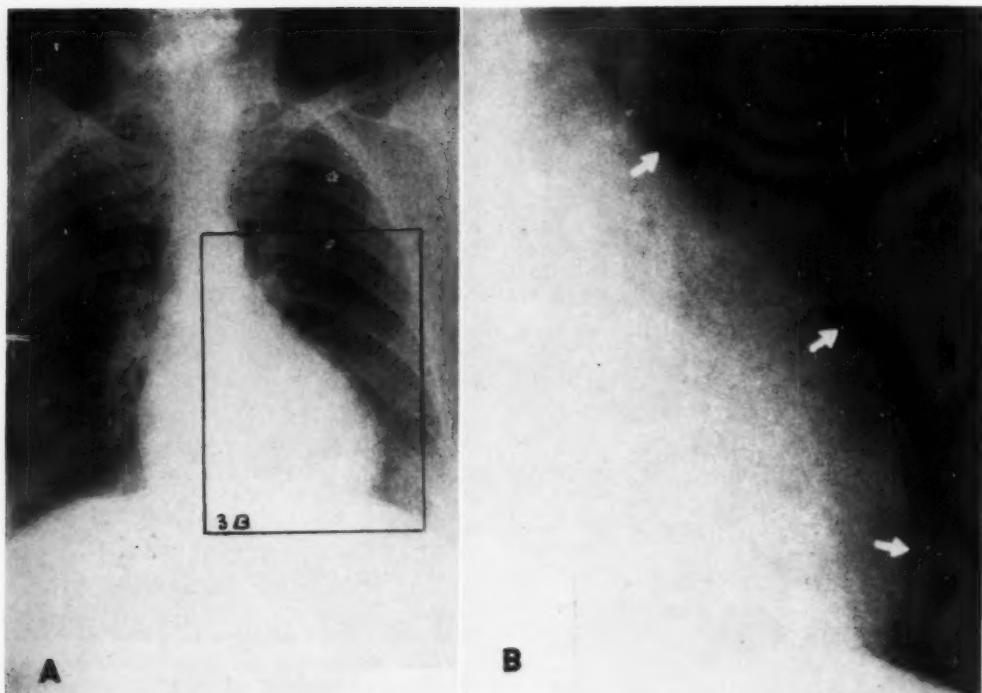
A. Roentgenogram of chest of a 61-year-old female, demonstrating the normal subepicardial-pericardial shadow pattern along the left heart border. B. Enlarged reproduction of indicated segment in 3A. All of the photographs of roentgenograms reproduced in this paper have been retouched to permit adequate visualization.
